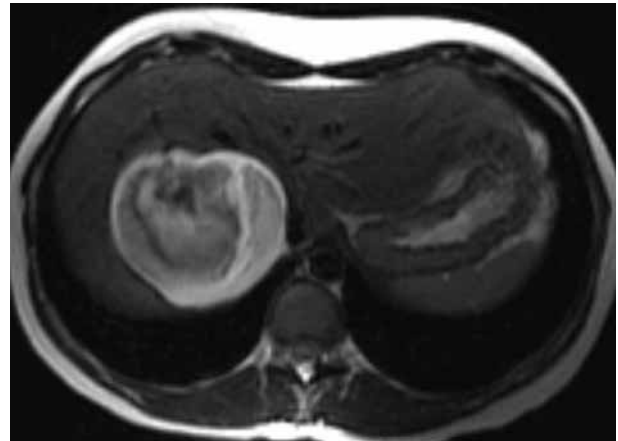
Axial T2-weighted MR image : the peripheral and central areas demonstrated increased signal intensity. The soft tissue component was also hyperintense. The calcification had low signal intensity.
